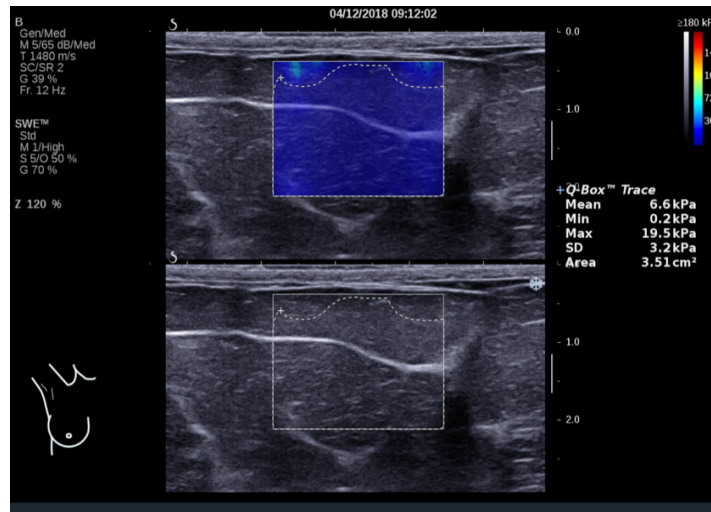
Free-Trace Q-Box™ on SWE image to omit ultrasound artefacts
